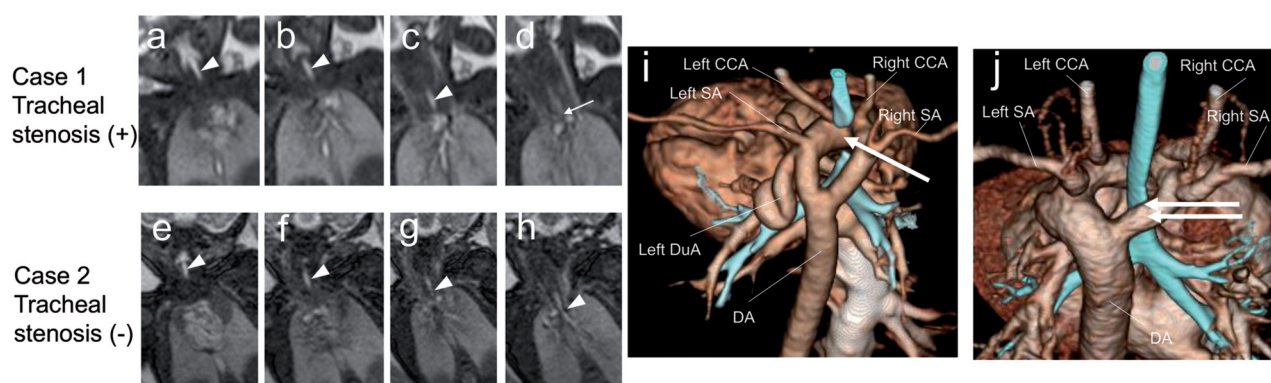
Fetal coronal T2-weighted MRI (Figures a-h) and three-dimensional CT (Figures i and j) of cases 1 and 2. Figures a-d: MRI of case 1 indicates that the trachea is clearly visible in its upper portion (Figures a-c: arrowheads), but it cannot be distinguished in its lower part around the great vessel loop (possibly around the double aortic arch) (Figure d: arrow) and the trachea cannot be followed for its entire length. Figures e-h: In case 2, the entire length of the trachea can be visualized (Figures e-h: arrowheads) and there is no “loss of continuity” observed in case 1 (Figure d: arrow). Figures i, j: CT image after the births of cases 1 (Figure i) and 2 (Figure j), a view from the patients’ dorsal side. A vascular ring due to a double aortic arch is evident (Figures i, j). Tracheal compression is evident in case 1 (Figure i: arrow), but not in case 2 (Figure j: double arrow). CCA: common carotid artery, DA: descending aorta, DuA: ductus arteriosus, SA: subclavian artery.
